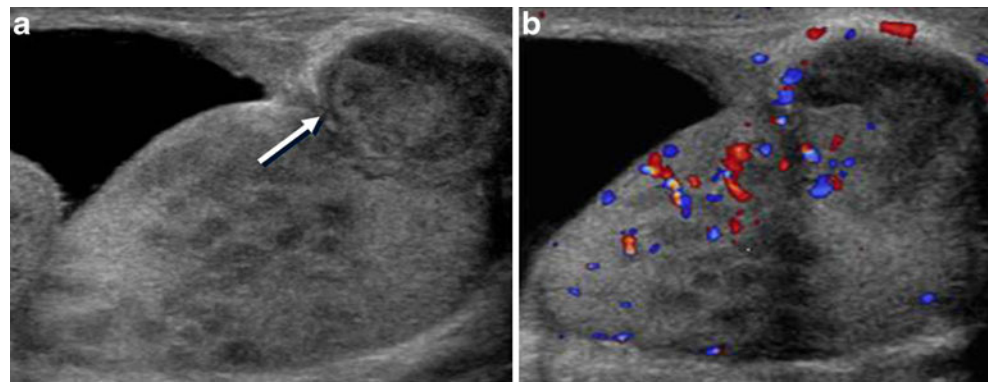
A 35-year-old man with tuberculous epididymo-orchitis of the left testis suffered from a left scrotal palpable mass. a Longitudinal US of the left testis shows mass-like enlargement (arrow) of the epididymis tail and multiple hypoechoic nodular lesions within the whole testis. b Colour Doppler US of the left testis shows increased peripheral vascularity
